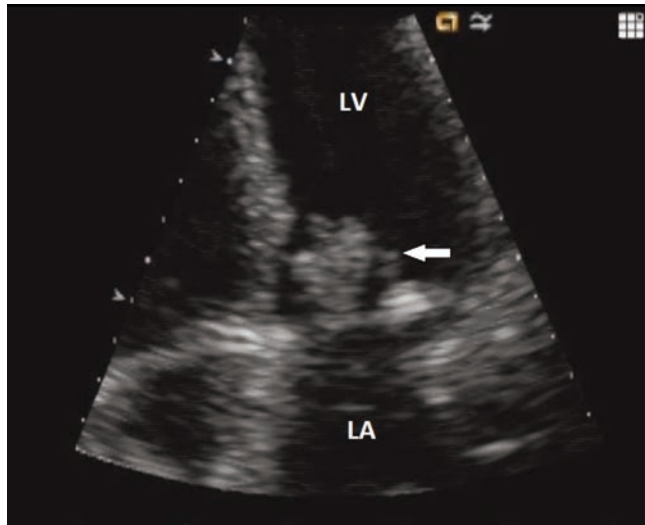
The repeat trans-thoracic echocardiogram is shown. The arrow points to the vegetation seen on the mitral valve. LV = Left ventricle. LA = Left atrium.
